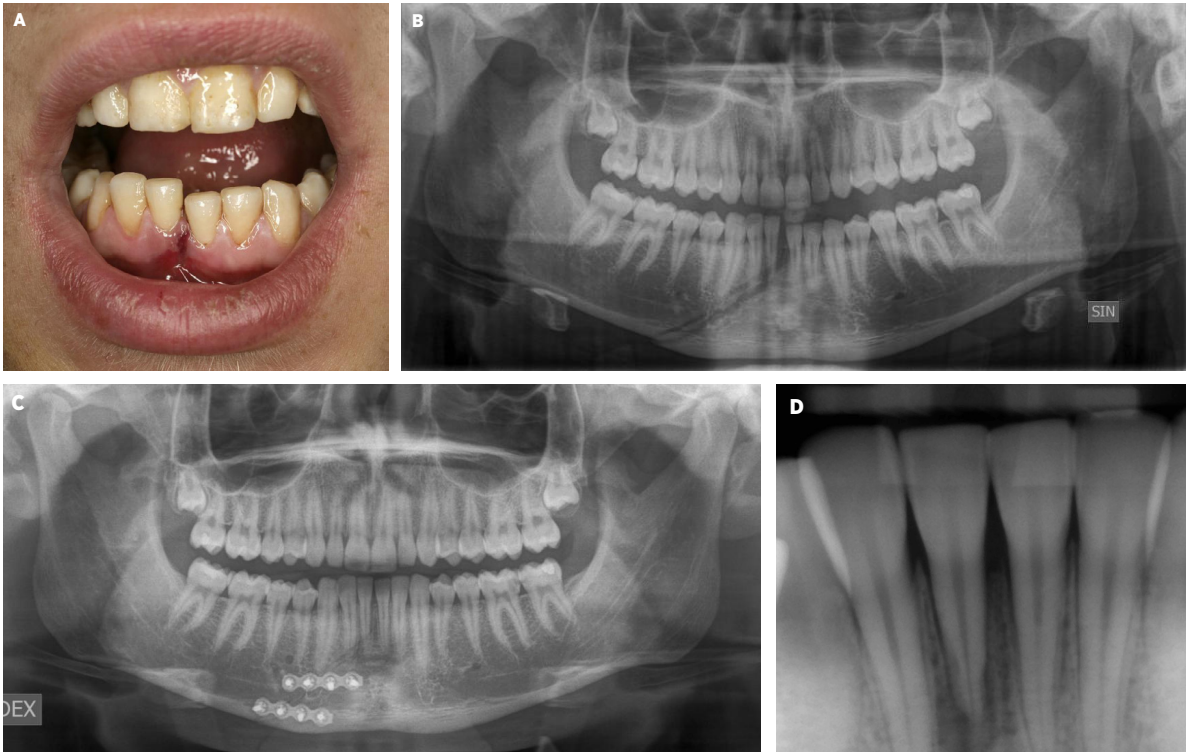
Fracture of the right parasymphysis area treated with two miniplates according to the technique described by Champy and Lodde (1976). A. Intraoral fractures site showing displacement. B. Preoperative radiological view of the mandibula. C. Postoperative radiological view. D. A periapical radiograph showing external resorption of d 41 three months after surgery.
